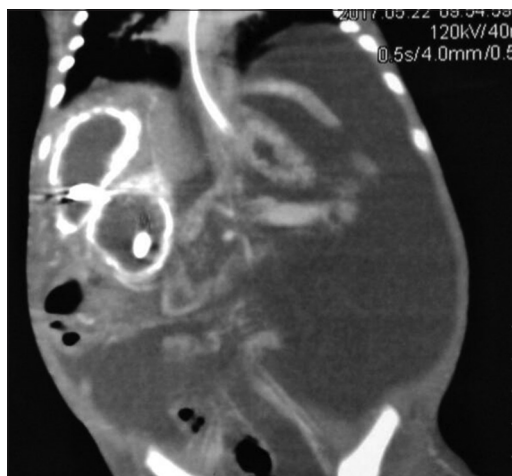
Coronal computed tomography image suggestive of two calcified liver abscess with portal vein cavernoma
